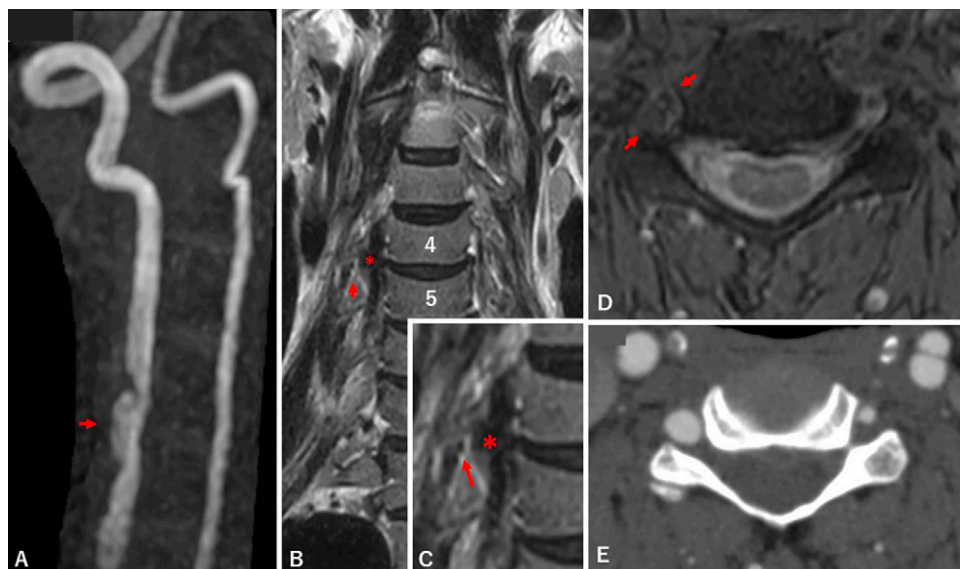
Cervical magnetic resonance angiography (MRA) shows the pearl-and-string sign (arrow) in the right VA (A). Coronal T2-weighted MRI shows that the expanded VA (asterisks) compressed the right C5 nerve root (arrows, B and C). The expanded VA filled the right C5 intervertebral foramen (arrows) on axial T2-weighted MRI (D) and computed tomography (CT) angiography (E). 4 = C4 vertebral body; 5 = C5 vertebral body.
